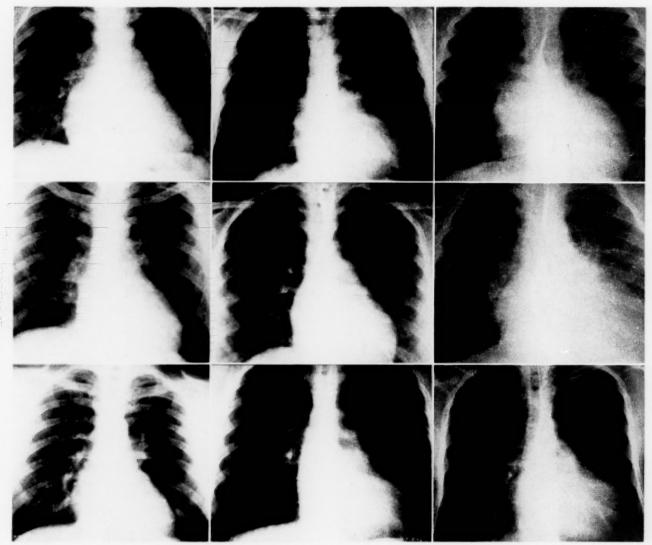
Anteroposterior roentgenograms, reading from top to bottom. Left, Cases III, IV and V. Middle, Cases VI, VII and VIII. Right, Cases IX, X and XI.
